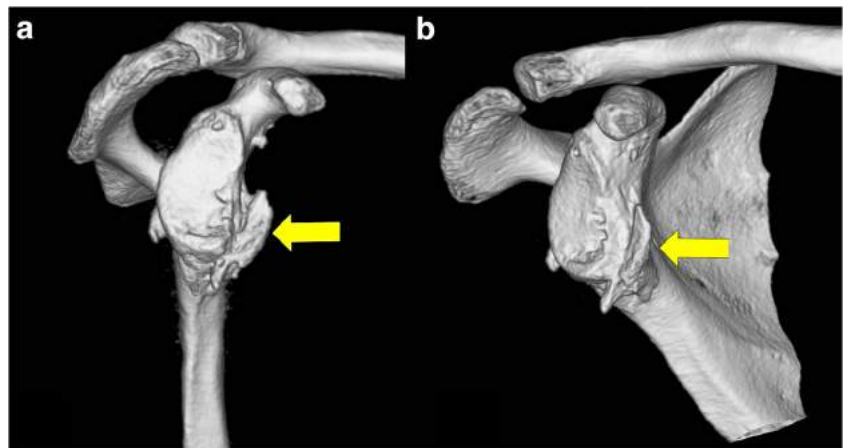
CT 3D volume-rendered reformat of the shoulder with the humeral head digitally removed demonstrating a large displaced bony Bankart fragment (arrow)
